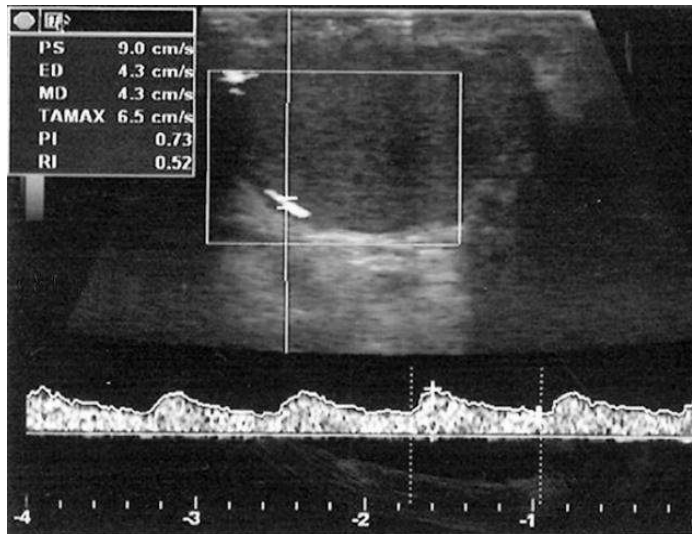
Transverse Doppler ultrasound image reveals RI and PI measurement in capsular artery in a 34 year-old patient.
